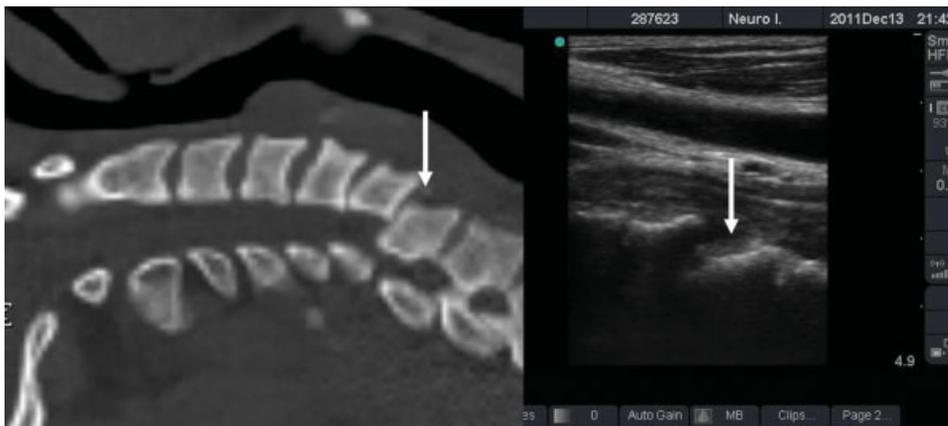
CT cervical spine (sagittal section) and ultrasound image of the cervical spine of a patient with bilateral facet dislocation at C5–6. The dislocation and disruption of the anterior longitudinal ligament in the cervical spine is very well seen on ultrasound imaging (arrow).
